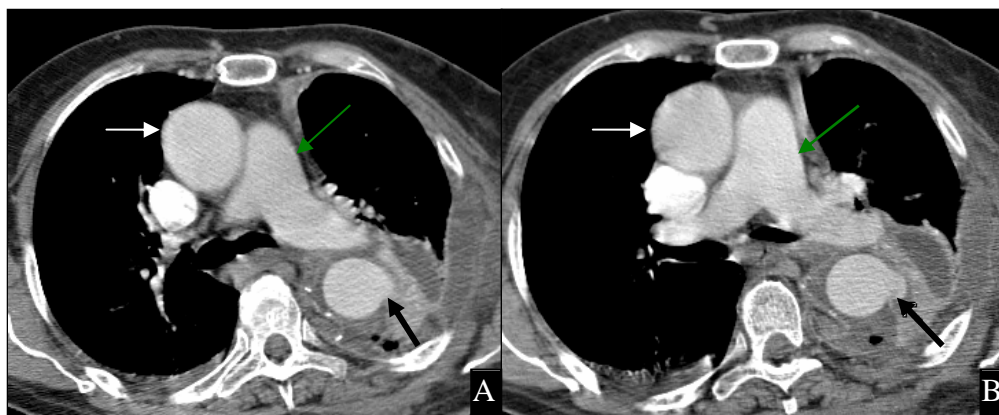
Patient is 2 weeks status post repair of a thoracoabdominal aneurysm. CT scan was interpreted as pseudoaneurysm versus cobrahead graft (black arrow) in the descending aorta. Post-operative changes present near the graft. White arrow = ascending aorta. Green arrow = pulmonary artery near the level of the bifurcation.
